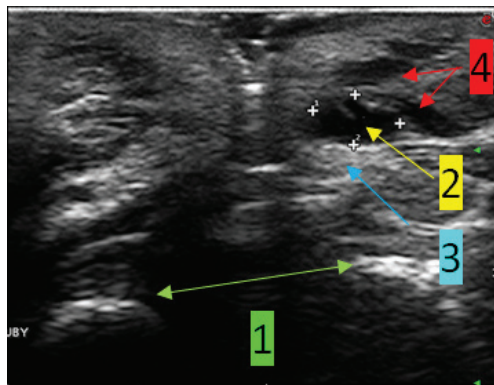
Sonogram of the lips, sagittal plane (arrow 1 – teeth). An anechoic HA filler bolus (arrow 2 - the anechoic filler bolus), oval shaped, with clear and even contours, with dorsal echo enhancement (arrow 2 – dorsal filler enhancement) without a fibrous capsule or perifocal edema of the lower lip soft tissues was visualized. The lip soft tissues have had a typical structure, the visualization of the orbicularis oris muscle wasn't hindered (arrow 4 – m. orbicularis oris). Echo signs of iatrogenic inclusions of HA origin into the lower lip soft tissues
